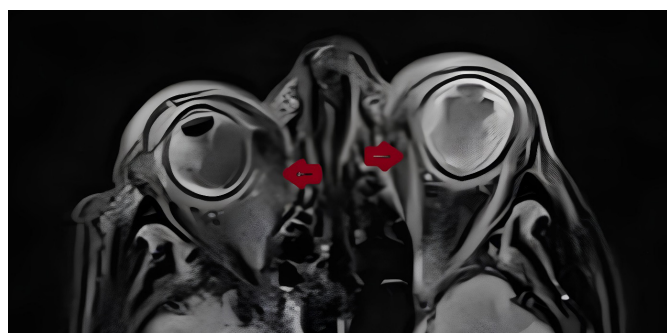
Orbital magnetic resonance imaging of the patient. There were diffuse edematous signal increases in bilateral cutaneous and subcutaneous tissues, more prominent on the left. An abscess was observed adjacent to the superior bulbous oculi on the left. There was an increase in signal in the intraconal area of the right eye (T2 sequence)
